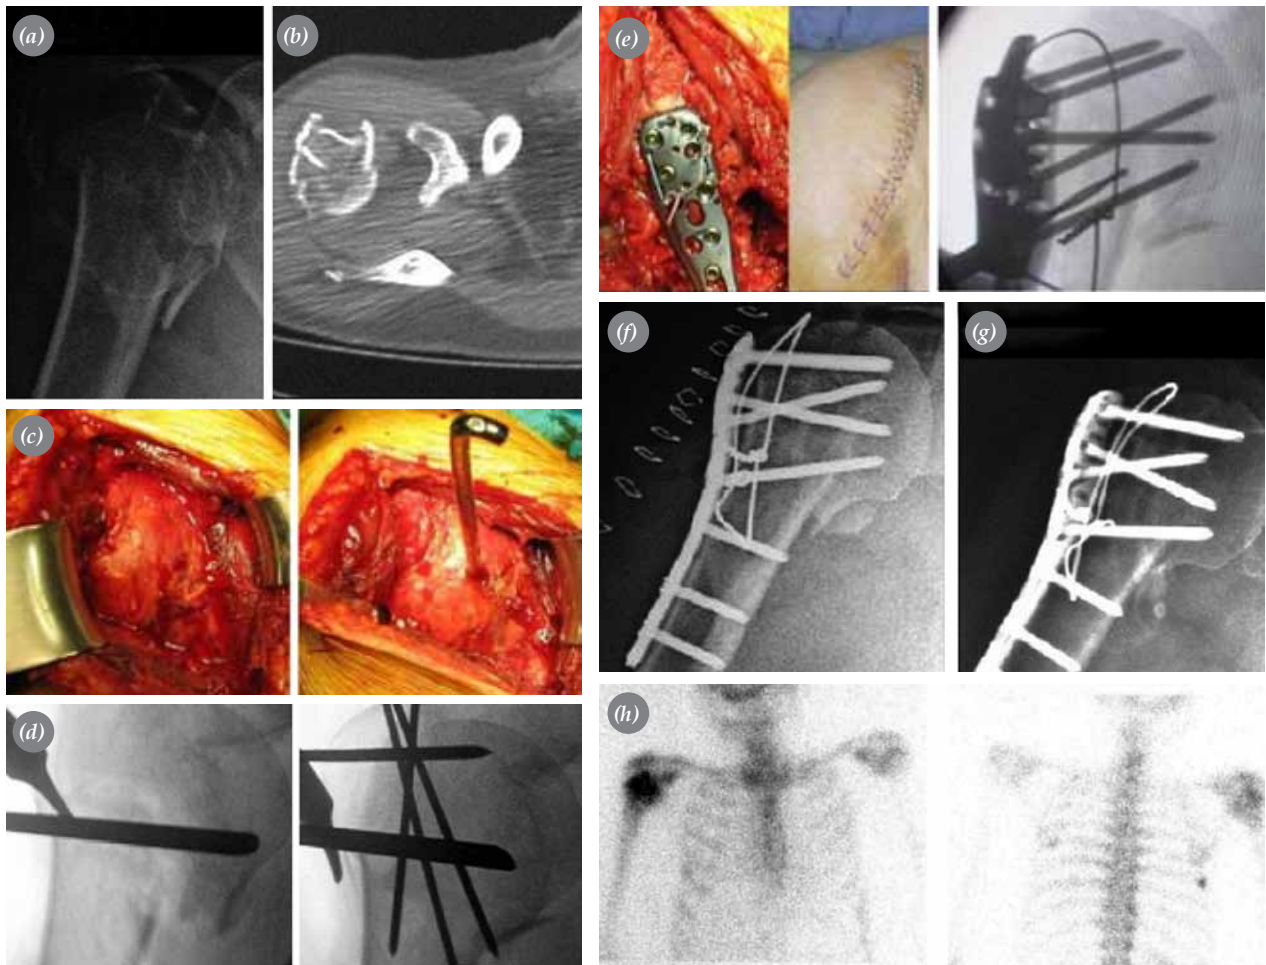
(a) The anteroposterior radiograph of a 66-year-old woman sustaining a four-part fracture of the left humerus after a fall. (b) Computed tomography clearly demonstrates the comminution of the fracture. (c) Intraoperative views of the fracture showing preservation of soft-tissue attachments to avoid further devascularization of the bone. (d) Intraoperative fluoroscopic views of the fracture showing a joystick to anatomically reduce the humeral head into the glenoid and Kirschner wires to temporarily keep the reduction of the fragments. (e) Intraoperative view showing fixation of the fracture using a locking plate. (f) Immediate postoperative radiograph shows reduction and internal fixation of the fracture using a locking plate and cerclage wire and an oblique screw inserted inferomedially to provide medial support. (g) Postoperative radiograph obtained at 12 months shows solid union of the fracture with no loss of reduction. (h) Bone scintigraphy performed at postoperative 12 months shows no sign of avascular necrosis.
